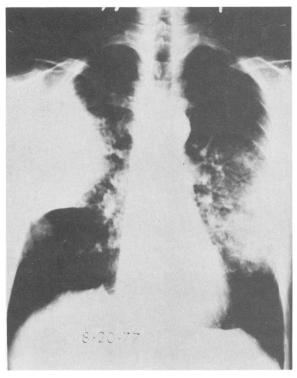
X-ray film of the chest made on the third day showing progression of pneumonia on right and spread to left middle and lower lung fields.
